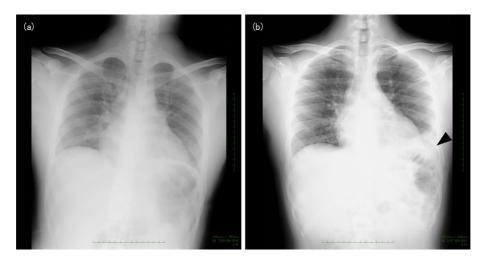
Chest X-ray on the second (a) and fifth (b) days of hospitalization. Note new consolidation (arrowhead) that appeared on the fifth day of hospitalization.
